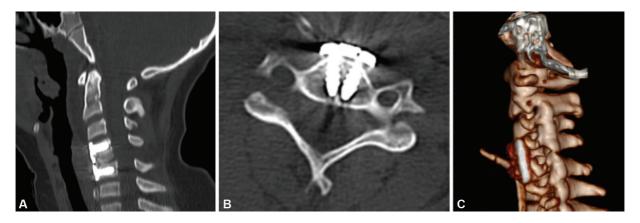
Postoperative images. (A) Sagittal CT scan showing the correction of the C4-C5 dislocation. (B) Axial CT scan showing adequate placement of screws in the anterior cervical arthrodesis (ACA) and C4 median fracture.
